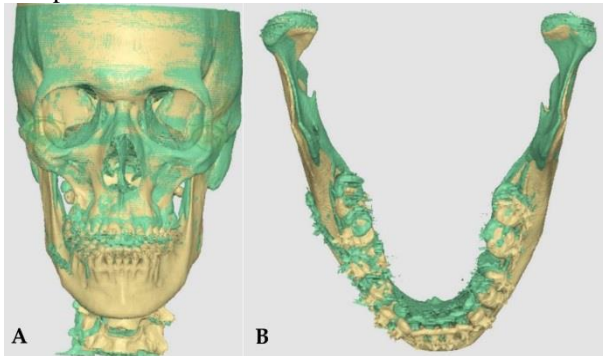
A & B showing postoperative CT and preoperative virtual planning superimposition.
